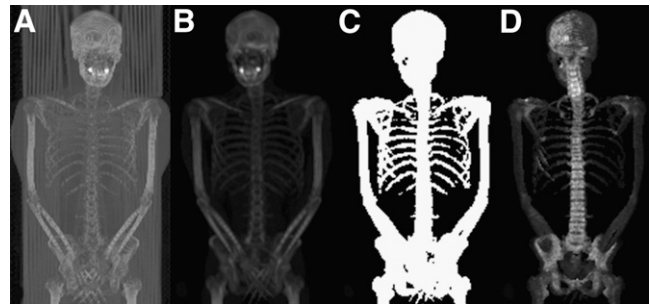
(A) The first step is to reformat CT image to dimensions of PET image. (B) Bed is eliminated by indicating most dependent part of body as image limit. (C) CT image is interactively thresholded to eliminate all soft tissue but keep bone densities. (D) PET image multiplied by mask leaves bone image with combined $^{18}\text{F}/^{18}\text{F}$ -FDG uptake.
